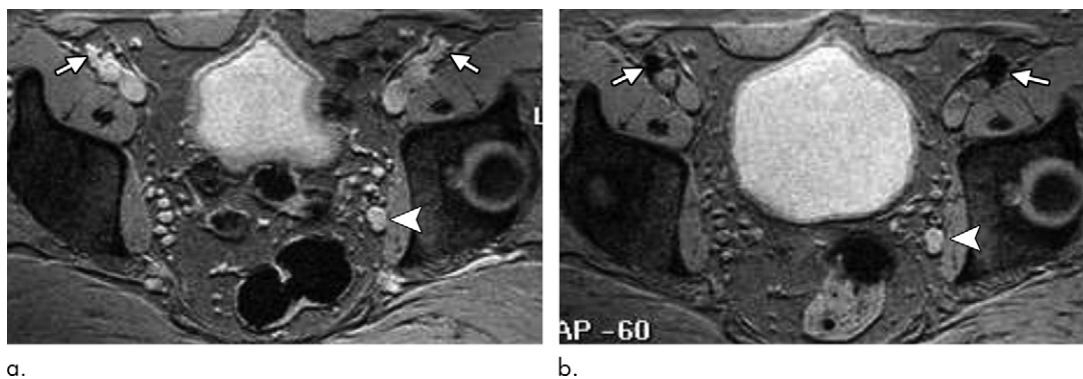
Ultrasmall superparamagnetic iron oxide (USPIO) MRI was used to detect nodal disease in a 65-year-old man with prostate cancer. (a, b) Axial T2*-weighted MRI (multi-echo data image combination, or MEDIC) before (a) and after (b) USPIO administration (intravenous feuromoxtran, 0.13 mL per kilogram of body weight) shows normal nodal contrast material uptake in normal external iliac lymph nodes (arrows), with reduced nodal signal after contrast material administration. On the other hand, a malignant left obturator node (arrowhead) shows no appreciable signal reduction after USPIO contrast material administration (Images courtesy of Dr Aslam Sohaib.)
